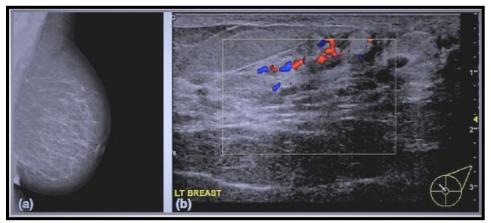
Duct ectasia. (a) Screening mammogram showing ductal distribution of needle shaped calcification in the left breast characteristic of duct ectasia. (b)Ultrasound shows multiple dilated ducts and intervening echogenic parenchyma with increased vascularity in the area of the mass. (24)
